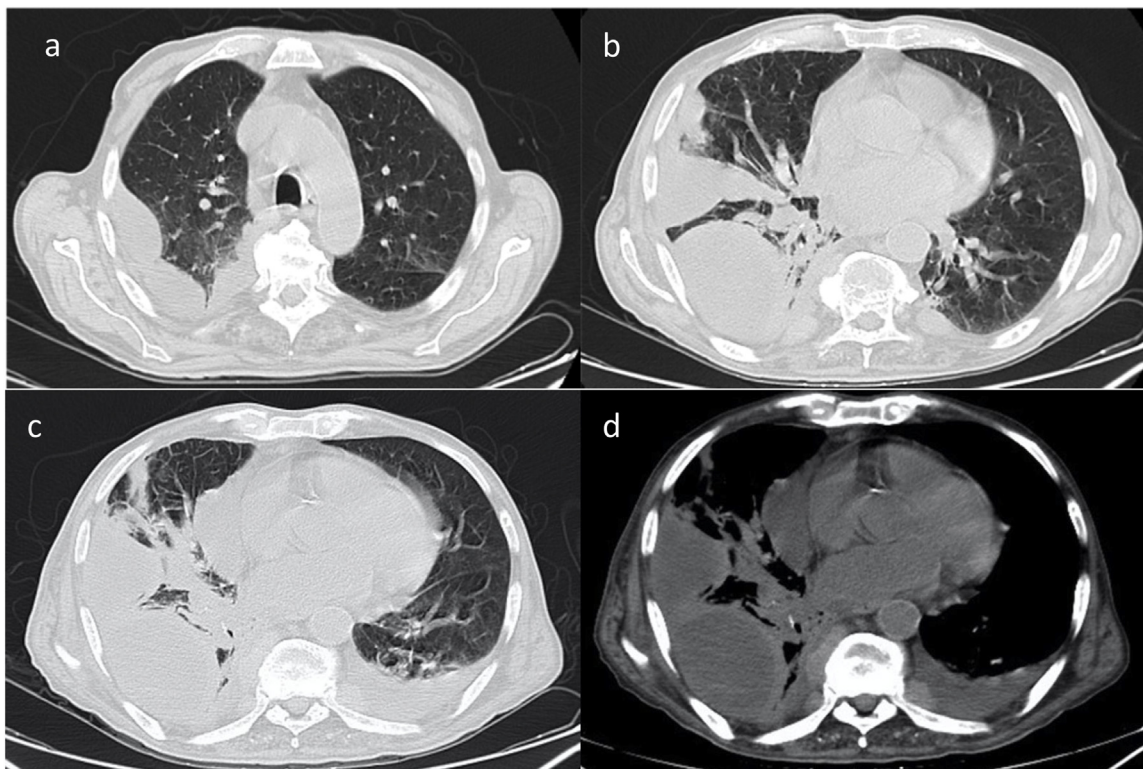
Chest CT axial images: (a), (b), (c) lung window and (d) mediastinal window showing right loculated pleural effusion with adjacent parenchymal consolidation and mediastinal lymphadenopathy.
